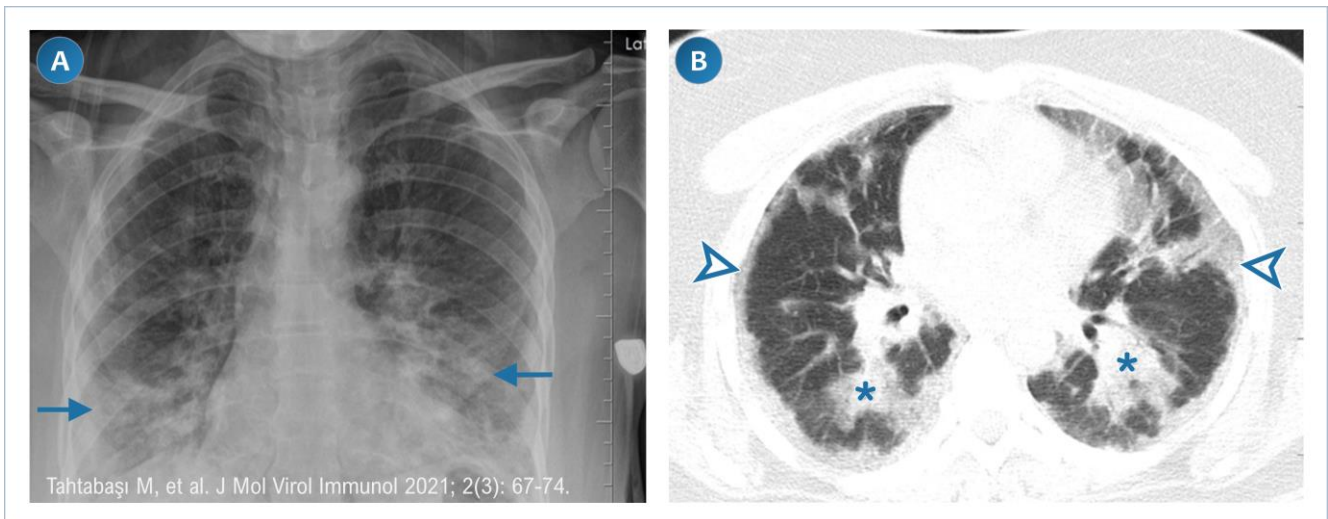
Chest X-ray and CT images of a 33-year-old male patient taken in January 2020. X-ray image (A) shows peripherally distributed opacities. CT images in the lung window (B,C,D) shows peripherally distributed ground glass opacities, and the reverse halo sign (arrowhead) with consolidated periphery and ground glass opacities in the center.
